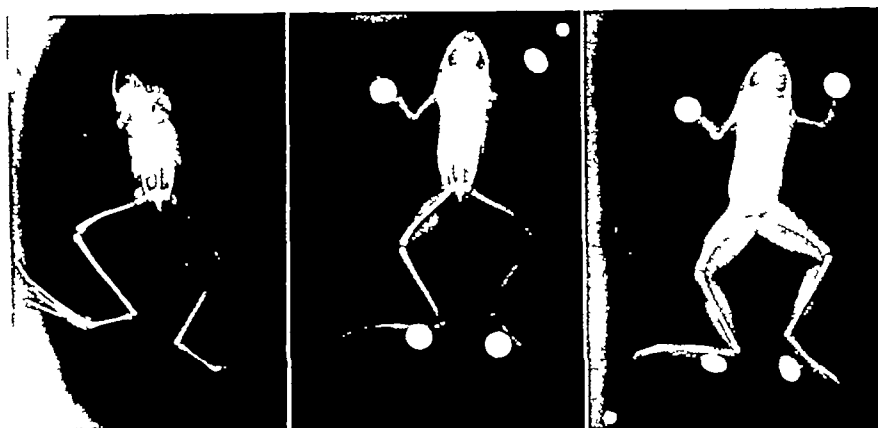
Radiographs of small frog made with monochromatic radiation and polychromatic radiation. From left to right: chromium monochromatic, molybdenum monochromatic, tungsten general radiation. All at 36 kv.
